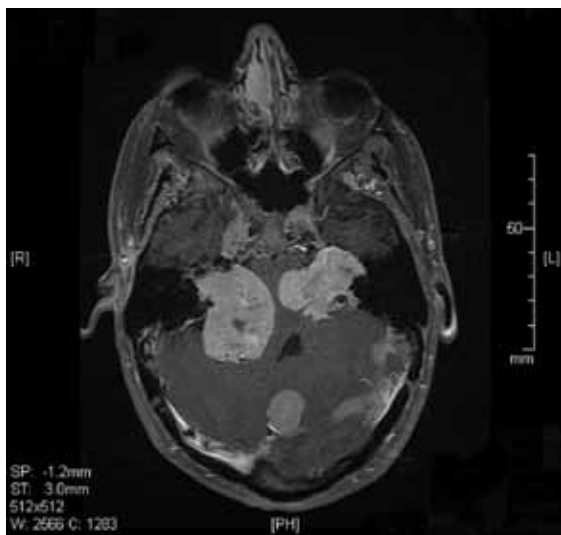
Gadolinium-enhanced MRI showing bilateral large vestibular schwannomas, a posterior fossa meningioma, and bilateral trigeminal nerve schwannomas.
